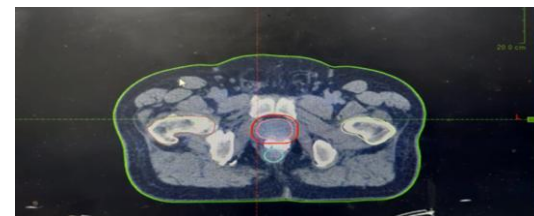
Axial planning CT with rectal and target contours
